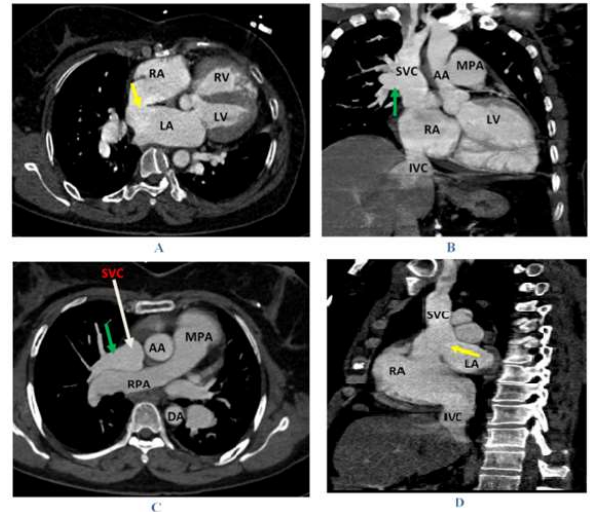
CT cardiac findings
